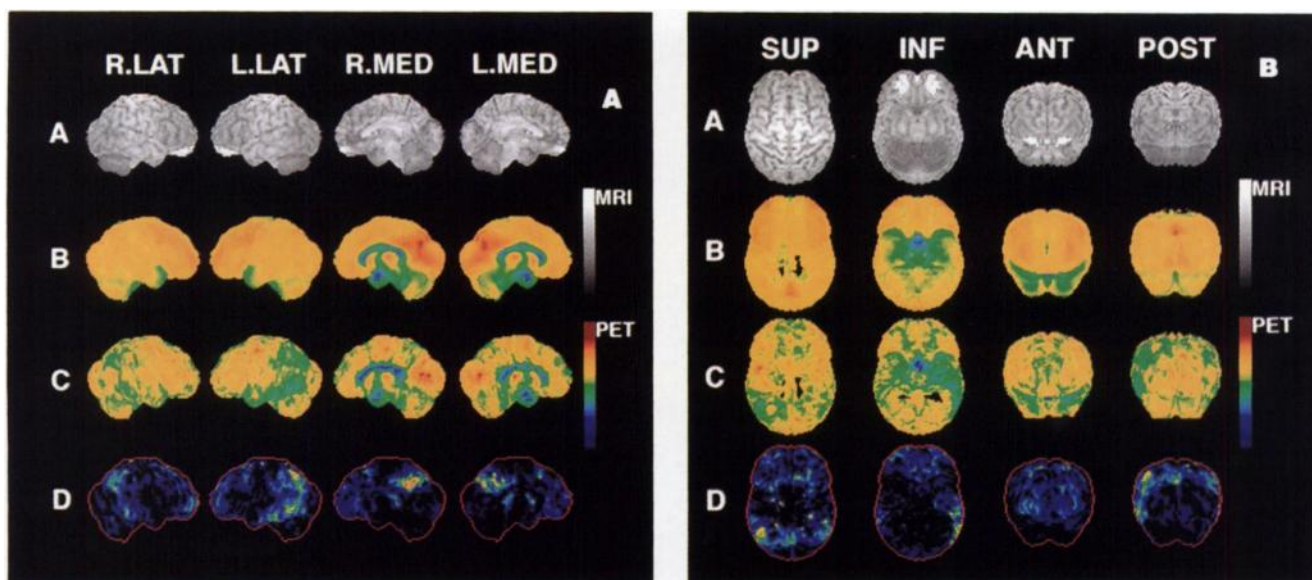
Three-dimensional stereotactic surface projections (3D-SSP). (A) Right lateral (R.LAT), left lateral (L.LAT), right medial (R.MED), and left medial (L.MED) views. (B) Superior (SUP), inferior (INF), anterior (ANT), and posterior (POST) views. Row A: Reference for surface anatomy of the brain revealed by MR imaging. Row B: 3D-SSP of a normal database representing mean pixel values averaged across 22 normal subjects on a pixel-by-pixel basis. Row C: 3D-SSP of CMRglc from a representative patient with Alzheimer's disease (70 year-old female, CDR = 1). Row D: 3D-SSP of statistical Z-scores representing areas of functional reduction in the patient in comparison with the normal database.
